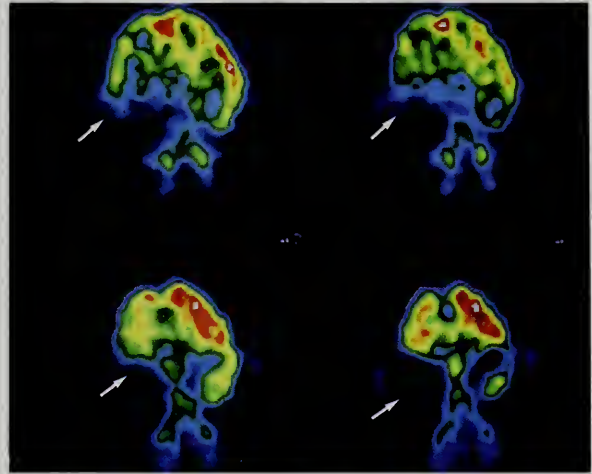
The EEG mapping in this epileptic patient with interictal surface recordings suggested bitemporal foci, while depth electrode recordings indicated a left temporal focus (A). The FDG-PET study (B), however, clearly localized the abnormality to the right temporal lobe (arrows), where markedly decreased glucose metabolism is evident.
